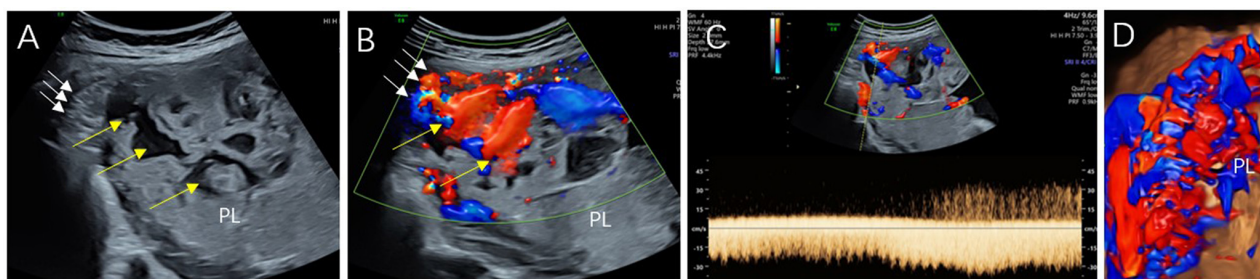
Ultrasound image of placenta accrete in uterine angle (PL, placenta). (A) For two-dimensional gray-scale ultrasound imaging, the white arrows indicate that the right angle and placenta are slightly protruding outward, the “clear zone” behind the placenta in the corner disappears, the myometrium of angle becomes thinner, and bridging blood vessels are visible. The yellow arrows indicate that there are multiple abnormal placenta lacunae in the placenta. (B) For Color Doppler ultrasound imaging, the white arrows indicate the hypervascularity and bridging vessels on the surface of the angle and in the myometrium, while the yellow arrows indicate the tributary vessels of the placenta lacuna. (C) Pulse Doppler ultrasound imaging show sawtooth spectrum at the entrance of placenta lacuna. (D) Three-dimensional Color Doppler ultrasound images show high vascularization on the surface of the angle and in the myometrium, as well as high vascularization in the placenta.
